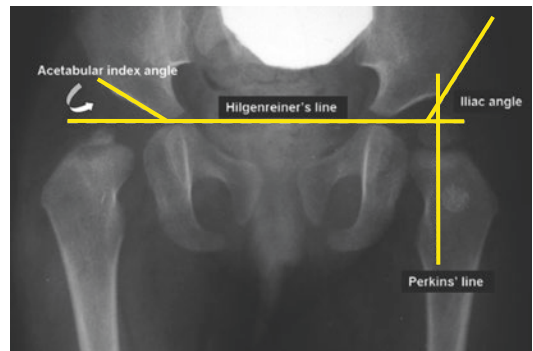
AP pelvic radiograph. The iliac index is the sum of both the AI and iliac angles bilaterally divided by 2
